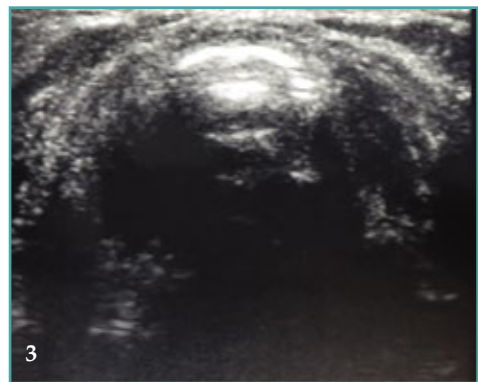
Ultrasonographic view of the CTM using the transversal technique (Photo by Lothar Schwarte).*
